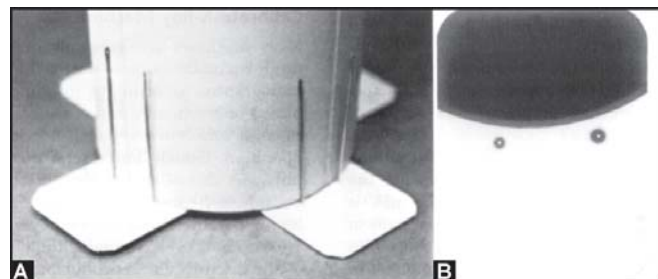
A. The alignment of the collimator of the X-ray beam and the end of the aiming cylinder can be checked by making a cross pattern of the film, centering the aiming cylinder, marking the periphery with needles and making an exposure. B. One of the processed radiographs showing the dark exposed area just inside the holes. If this pattern is seen on all films, then good alignment is demonstrated
